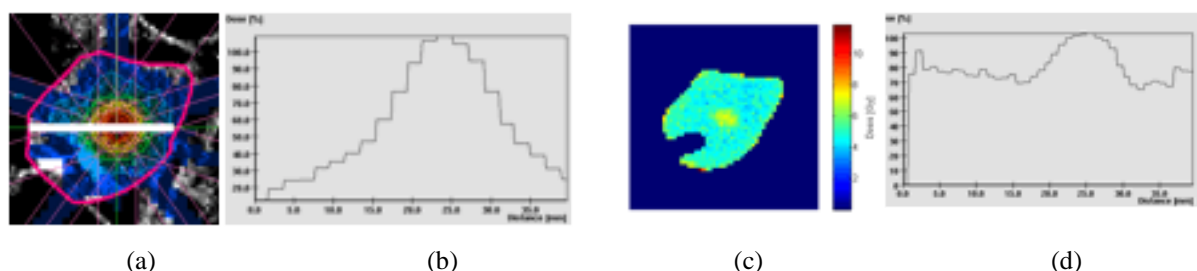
CT-based dose-distribution (a) and normalized dose profile (b) along the white line. (c) and (d) show the respective results of the gel measurement.
